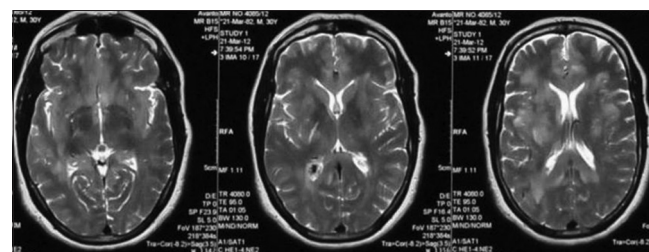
MRI brain with FLAIR sequences
